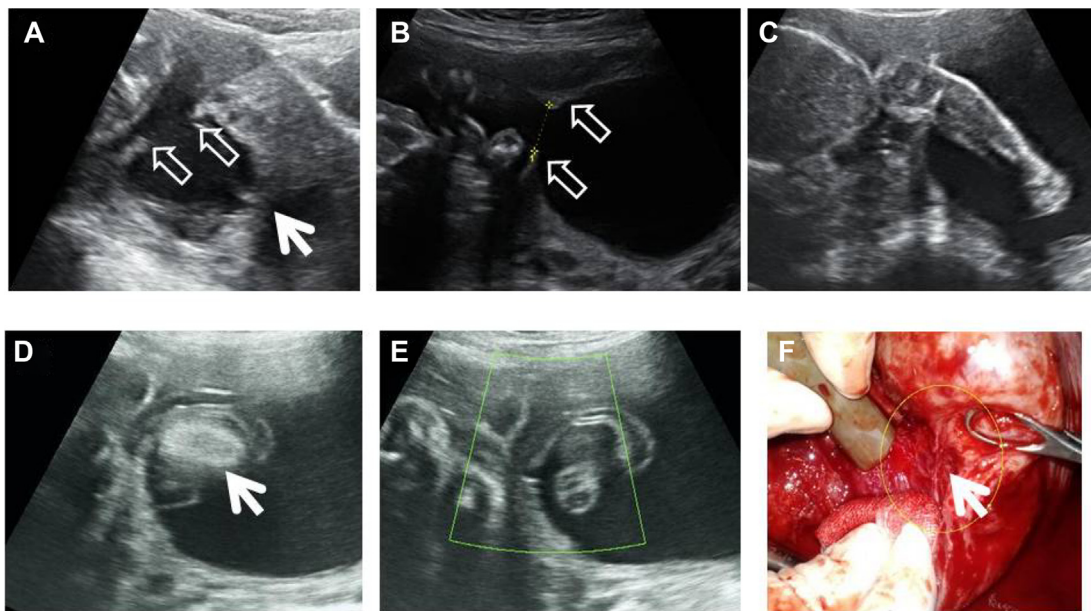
(A) At 22 weeks' gestation, the horizontal synechia band was visible at the uterine lower portion (open arrows: synechia bands, white arrow: cervix). (B) At 24 weeks' gestation, the size of the lower pocket became larger compared with the upper pocket (open arrows: synechia bands). (C) At 26 weeks' gestation, the fetal left leg was projected through the synechia band. (D) At 30 weeks' gestation, the cord and fetal left leg were projected through the synechia band (white arrow: fetal left leg). (E) At 30 weeks' gestation, ultrasound showed the cord and fetal left leg projected through the synechia band; color Doppler imaging showed no blood flow into the umbilical cord. (F) Surgical finding: this is the opened uterine body. Two fingers in the left upper corner grasped the hose for blood suction. The ring forceps at the right side grasped the opened uterus. Dense intrauterine synechia band was visible (white arrow) in the internal surface of the uterus.
